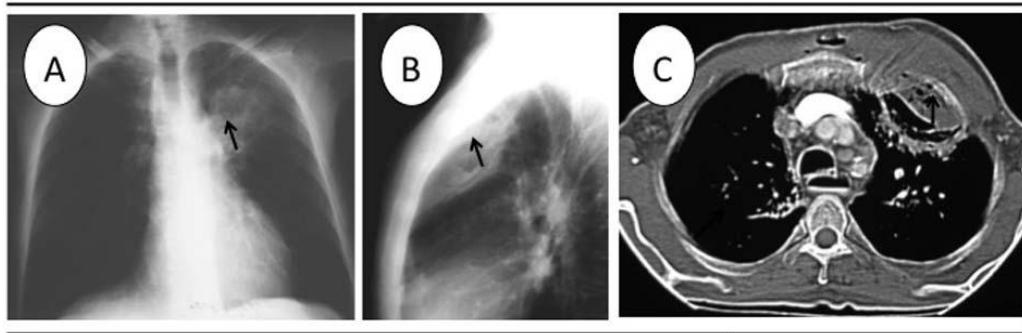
75 year old male with uncontrolled diabetes, presenting dyspnea, anterior chest wall pain and rusty sputum. The consolidation of the anterior segment of the upper left lobe (arrow) in close contact with the chest wall. The CT confirmed the rib involvement (arrow). *Mucor* was isolated on the biopsy as the germ causing the inflammation.
